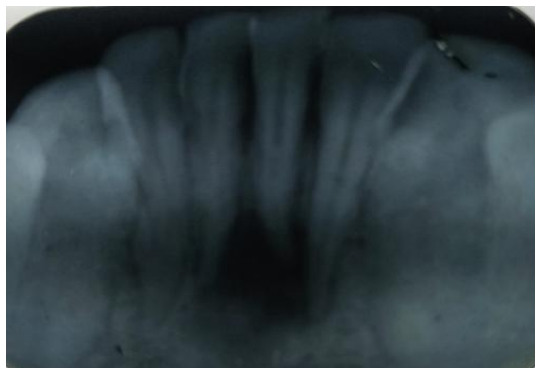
Preoperative radiograph showing Periapical radiolucency of both central incisors
